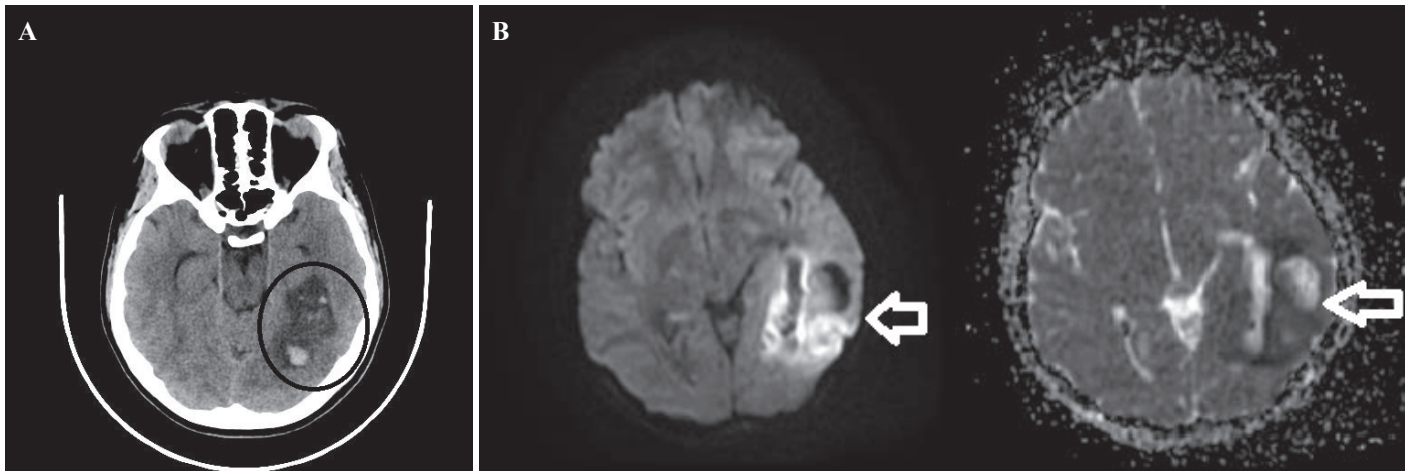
(A) A non-contrast-enhanced CT scan of the patient's brain revealed a large area located in the left parietooccipital region of the brain. A hypodense lesion (black circle) exhibiting hyperdense hemorrhagic foci was detected, indicating hemorrhagic venous infarction. (B) Diffusion MRI examination of the brain was performed at various stages, revealing diffusion restriction (indicated by arrows) that is consistent with the presence of an area of acute infarction in the left parietooccipital region and includes hemorrhagic components.
